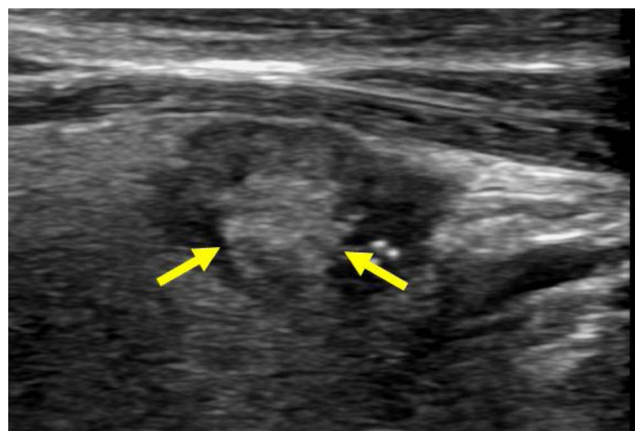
58 year old woman with papillary carcinoma. Longitudinal ultrasound of the right thyroid demonstrating a non-shadowing area of isoechoic tissue centrally located within a nodule (arrow) consistent with the central echogenic area finding.
